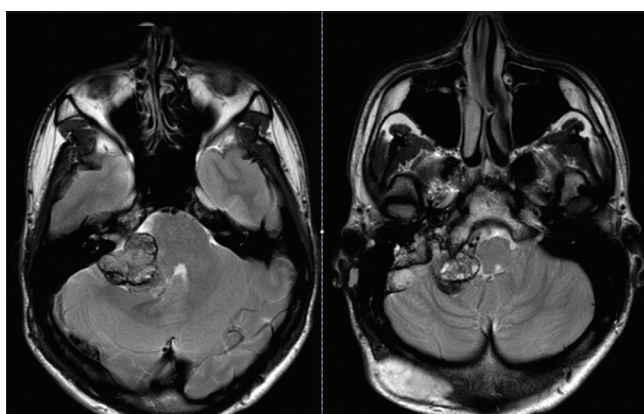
Preoperative T2 magnetic resonance imaging
